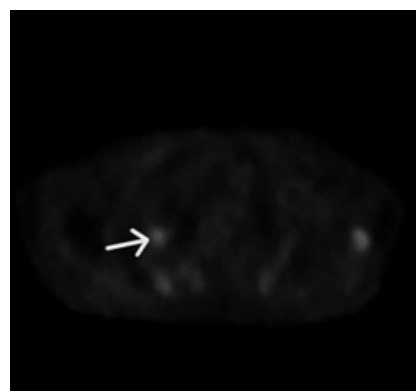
PET-CT with 18F-FDG showing intense uptake in the area of interest (arrow).
